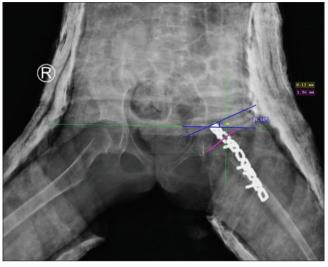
Post-operative radiograph in patient 4
